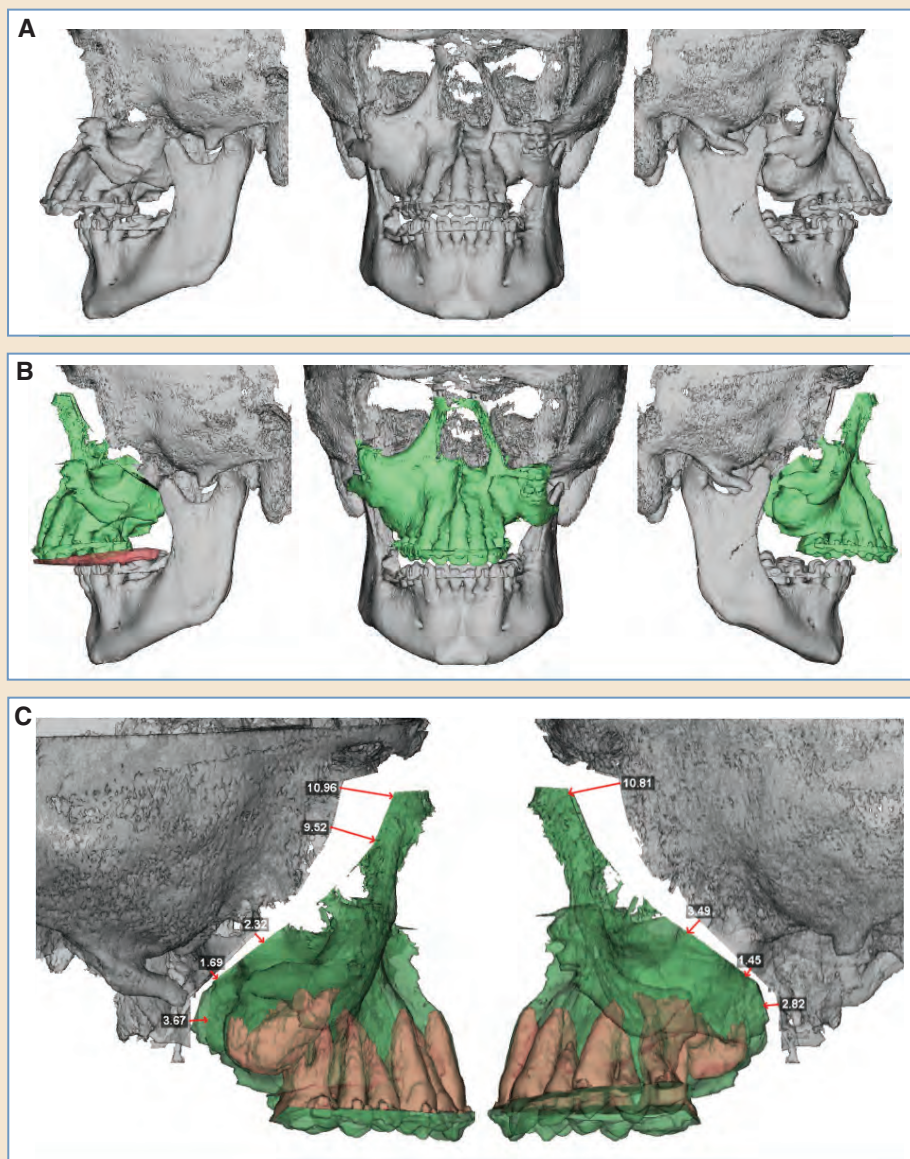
VSP to correct a complex craniofacial deformity after a LeFort III midface advancement. A, 3D CT images show counterclockwise rotation of a LeFort III segment. B, VSP was performed to plan a clockwise derotation of the LeFort III segment. C, Cephalometric projections from the planned movement are demonstrated.
